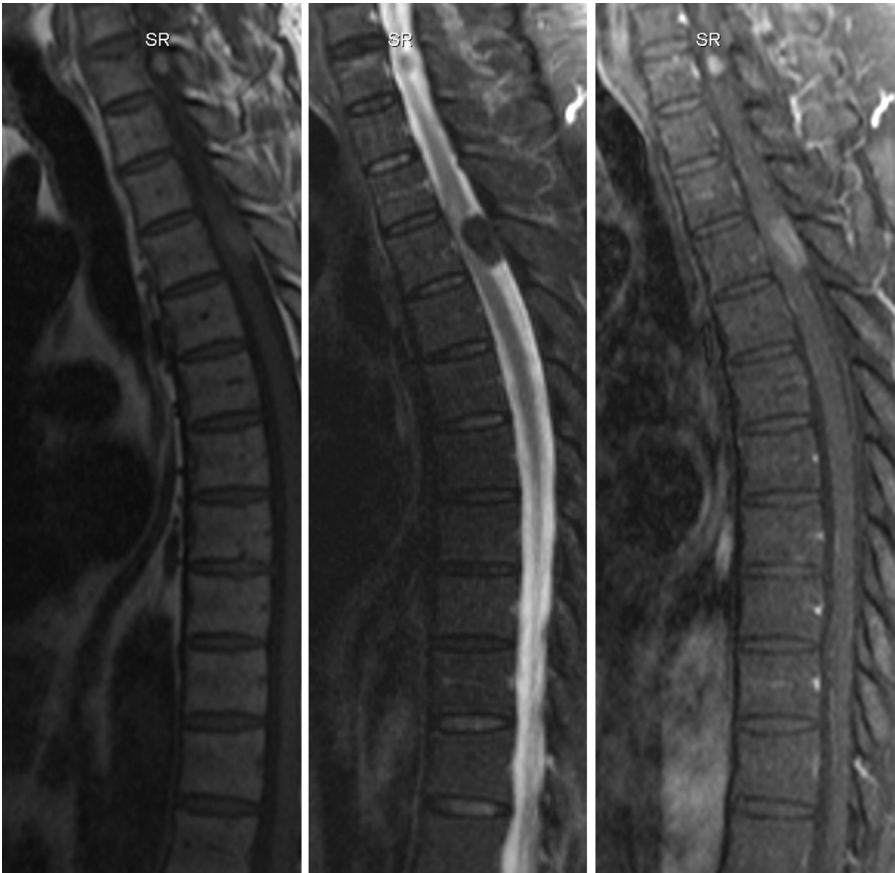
Preoperative MRI images. Preoperative MRI of the thoracic spine revealed two intradural extramedullary lesions at the T1 and T3–T4 levels. Both lesions were hyperintense on T1 (Left) and hypointense on T2 (Middle); following the administration of contrast agent, they showed homogeneous enhancement (Right). MRI, magnetic resonance imaging.
